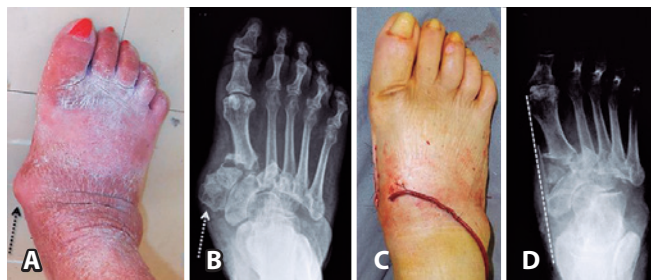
Localized prominence in the medial aspect of the right foot (dark dotted arrow) (1A) corresponding to the bony prominence of the medial and intermedial wedge, which is identified in the radiographic image of the foot (light dotted arrow) (1B). After surgical resection, improvement is visible in the foot contour (1C), with corresponding elimination of the bony prominence (clear dashed line) (1D).
